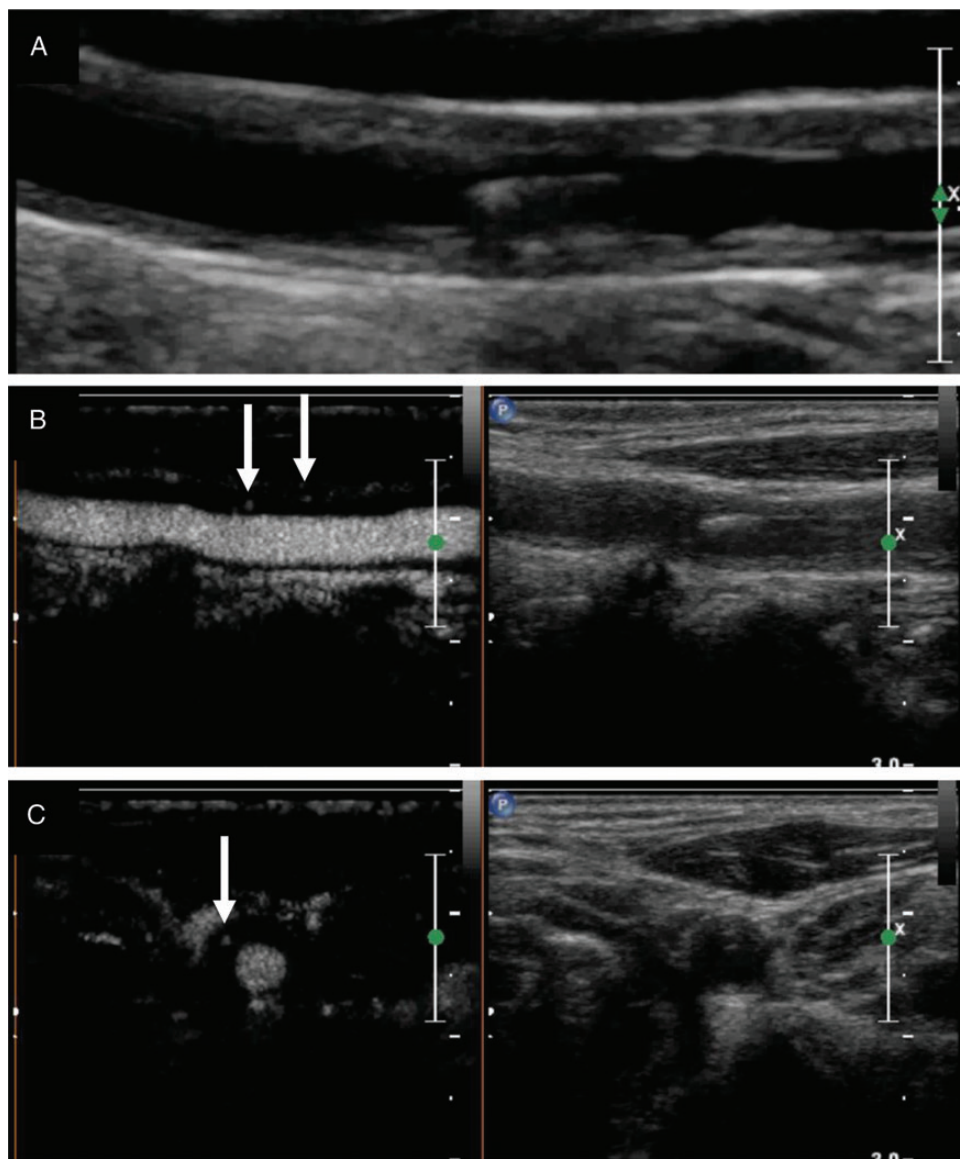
Carotid B-mode ultrasound and CEUS in a 64-year-old woman with Takayasu arteritis (Case 2 from *Table 1*). (A) Longitudinal B-mode ultrasound demonstrating marked carotid wall thickening. (B) Longitudinal side-by-side carotid CEUS (left panel) and B-mode ultrasound (right panel). The microbubble contrast agent improved the borders of the vascular lesion, and the arrows indicate microbubble contrast agent within the vascular wall lesions, indicating wall vascularization (*vasa vasorum*) (Supplementary data online, *Movie S1*). (C) Transversal side-by-side carotid CEUS (left panel) and B-mode ultrasound (right panel). The contrast agent improved delineation of the carotid lumen; there is marked circumferential thickening of the vascular wall. The arrows indicate microbubble contrast agent within the vascular wall lesions, indicating carotid wall vascularization (Supplementary data online, *Movie S2*).
